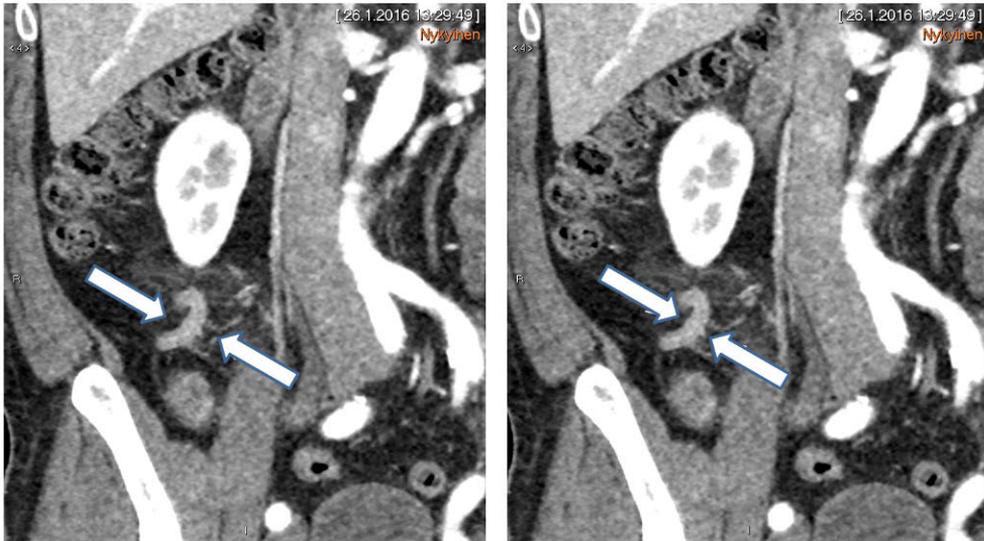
CT image of uncomplicated acute appendicitis in the same patient. A) Contrast-enhanced low-dose protocol (thick arrows: appendix). B) contrast-enhanced standard protocol (thick arrows: appendix).
